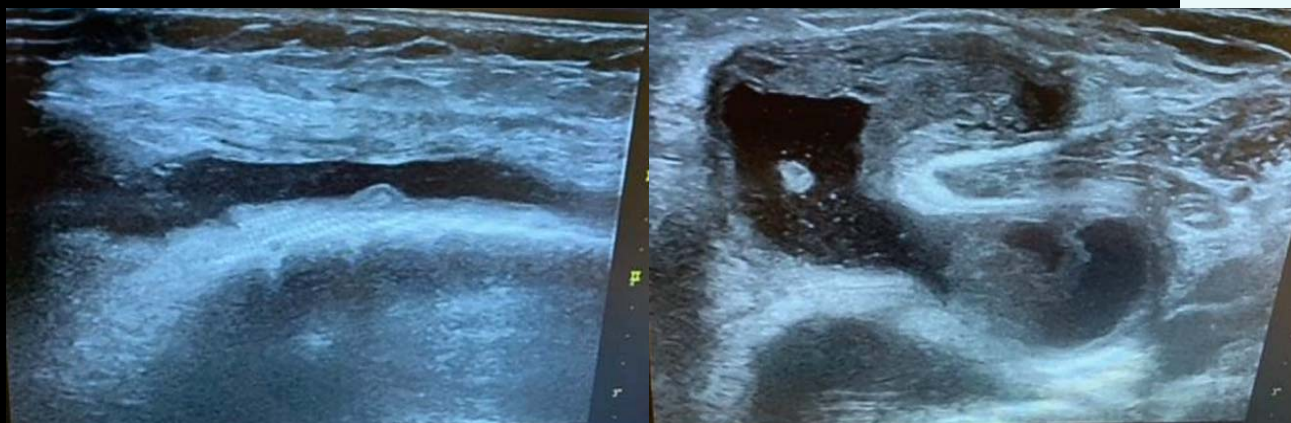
Left knee ultrasound with para-patellar fluid and Baker's cyst
